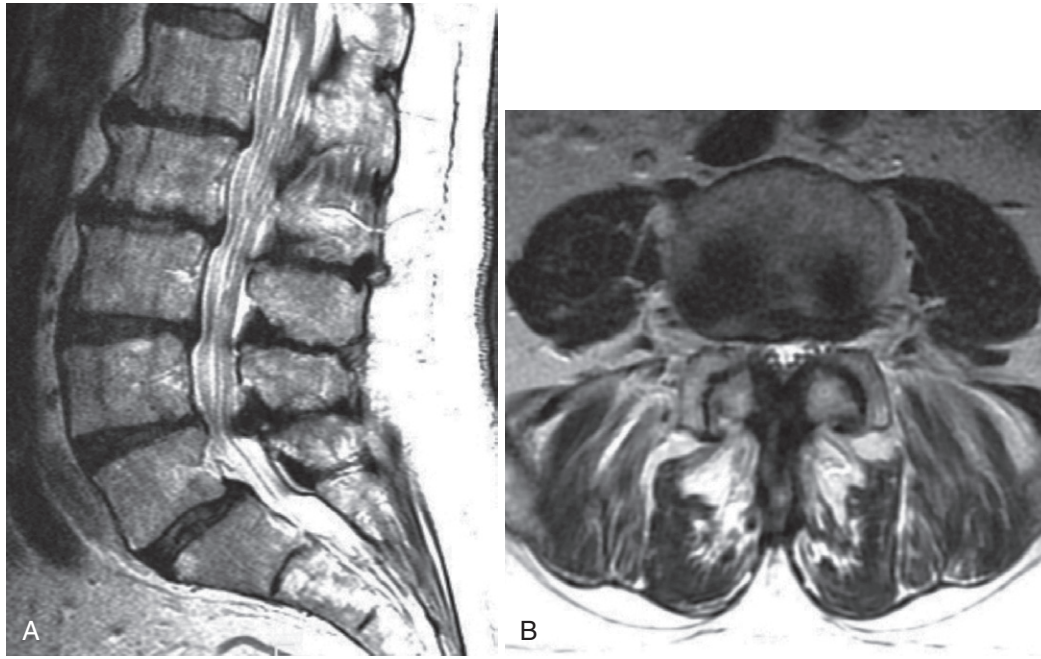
Degenerative spinal stenosis. A, The sagittal T2-weighted magnetic resonance image shows decreased anteroposterior diameter of the neural canal at the L4-5 level due to redundancy of the ligamentum flavum. B, The axial image through the L4-5 disk shows decreased cross-sectional area of the thecal sac from hypertrophic changes of the facet joints posterolateral to the thecal sac. (Courtesy Dr. John Crues, University of California, San Diego.)
